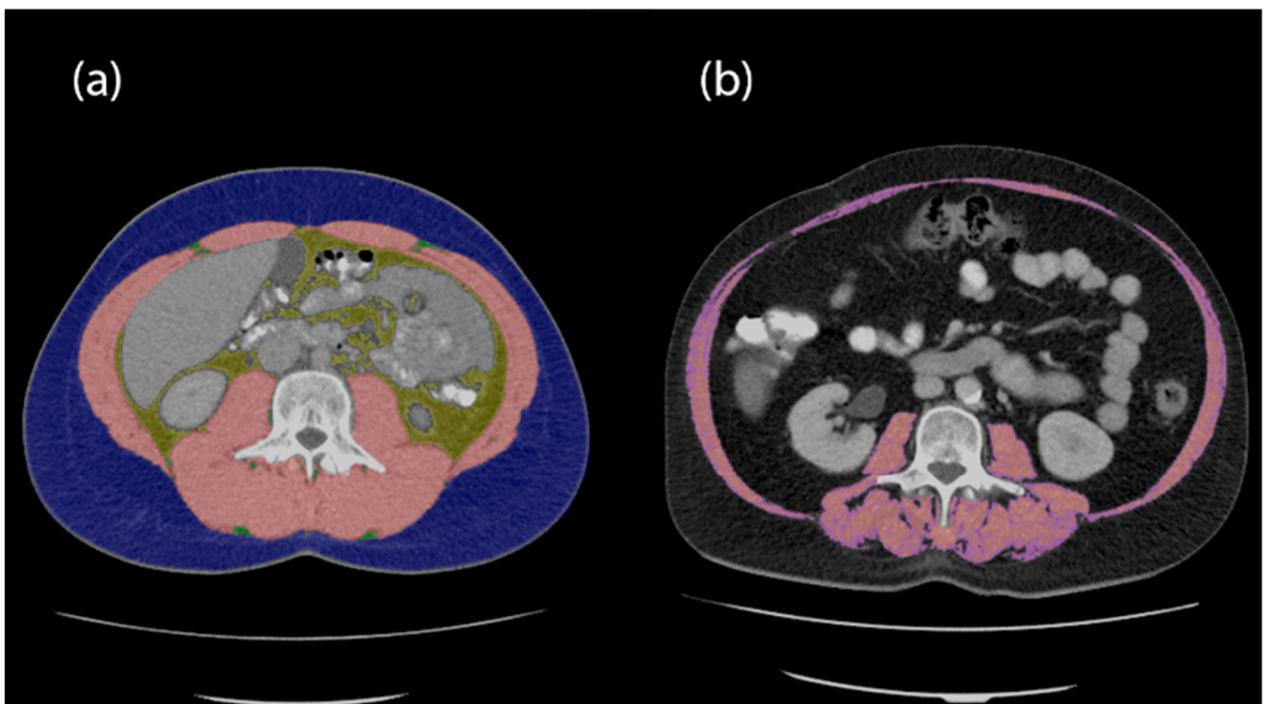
CT-ermittelte Körperzusammensetzung auf Höhe des dritten Lendenwirbels (L3): (a) blau, SAT; rosa, SMT; grün, IMAT; und gelb, VAT. (b) lila, SM-RA (-30 bis 30 HU).
